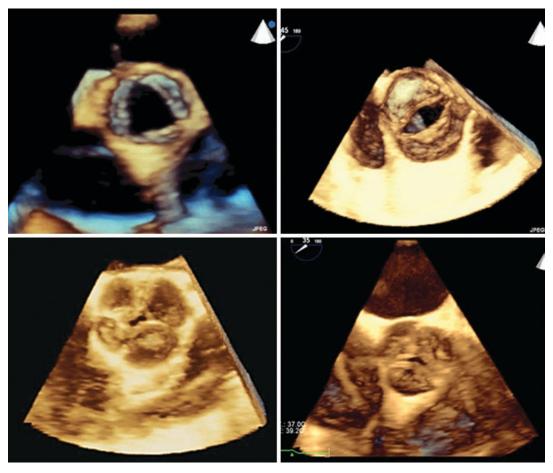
Surgical view of the mitral valve with transthoracic (left panel) and transesophageal (right pane) echocardiography of the same patient. With both approaches a flail P2 prolapse with ruptured chordae is clearly defined
